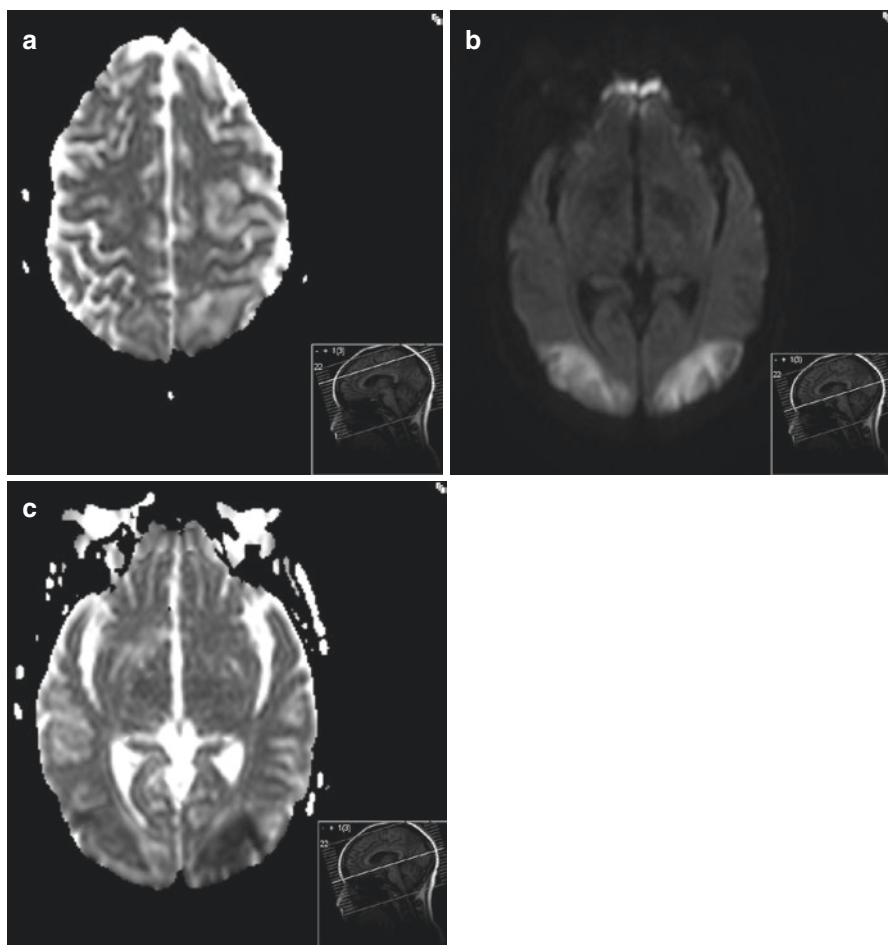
ADC map and DWI showing restricted diffusion and a low apparent diffusion coefficient (ADC) in the occipital regions, but not in the frontal ones
